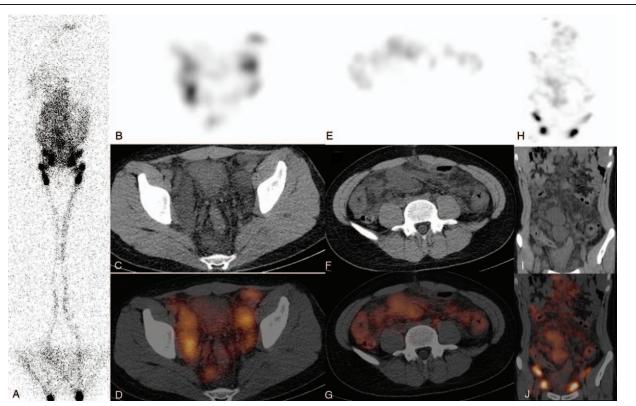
Representative images of lymphangioma in patient 5. (A) Anterior image of lymphoscintigraphy obtained 1 h after ^{99m}Tc-ASC injection; (B–D) axial SPECT, CT, and fusion images of the pelvis; (E–G) axial SPECT, CT, and fusion images of the abdomen; (H–J) coronary SPECT, CT, and fusion images of the abdominopelvic region.
